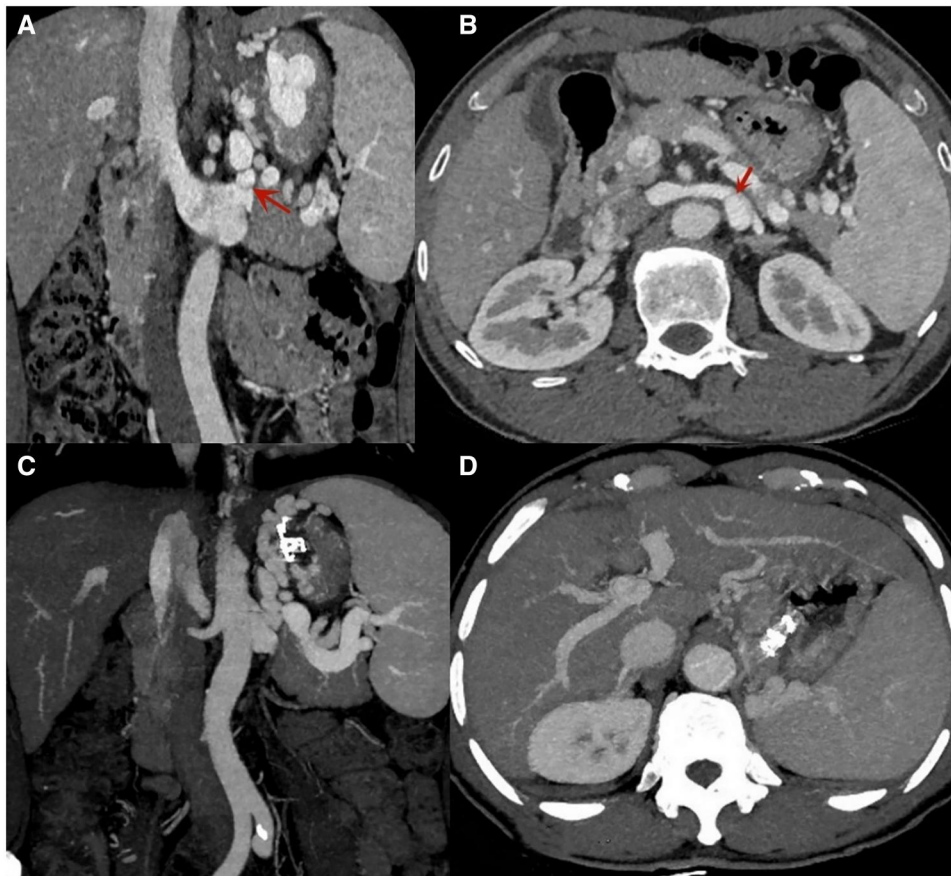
Preoperative and postoperative CTA of the portal vein. (A–B) CTA of the portal vein showed gastrorenal shunt in gastric varices (red arrow) preoperatively. (C–D) 1-week postoperative CTA of the portal vein showed that the coil did not migrate and was within the target vessel. CTA = computed tomography angiography.
